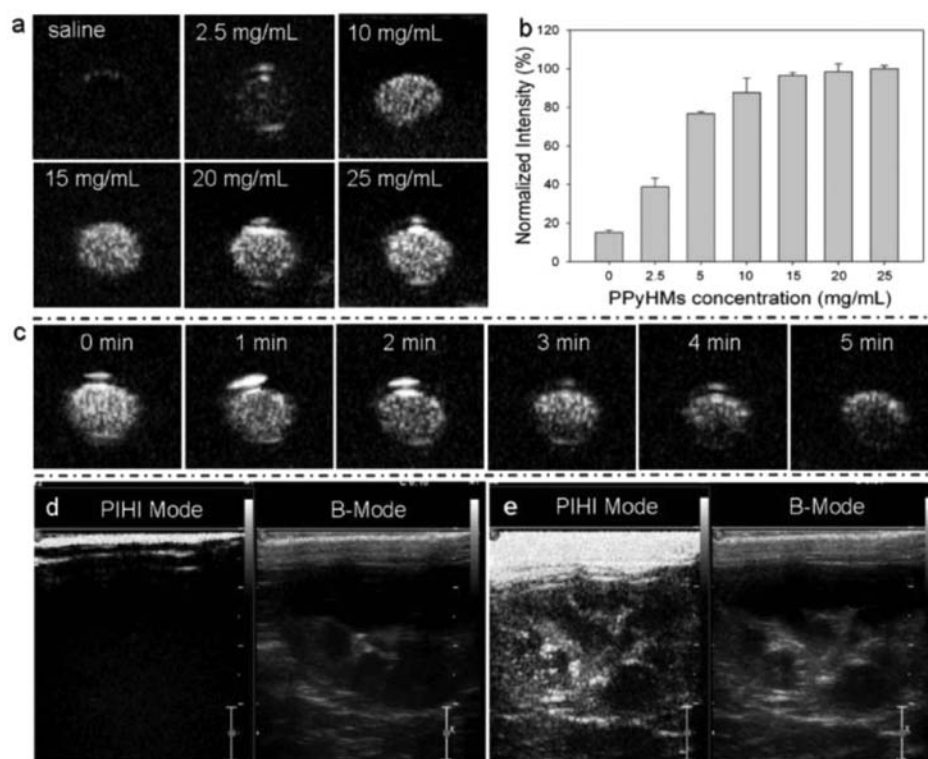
In vitro* ultrasound contrast-enhanced images in a latex tube: (a) US images of various concentrations of PPyHMs. (b) Normalized US intensities over PPyHMs concentration. (c) Time-dependent echogenic behaviors of PPyHMs at the concentration of 20 mg mL⁻¹. *In vivo* ultrasonograms in the rabbit right kidney (d) pre- and (e) postadministration of PPyHMs. Reprinted with permission from ref 108.
